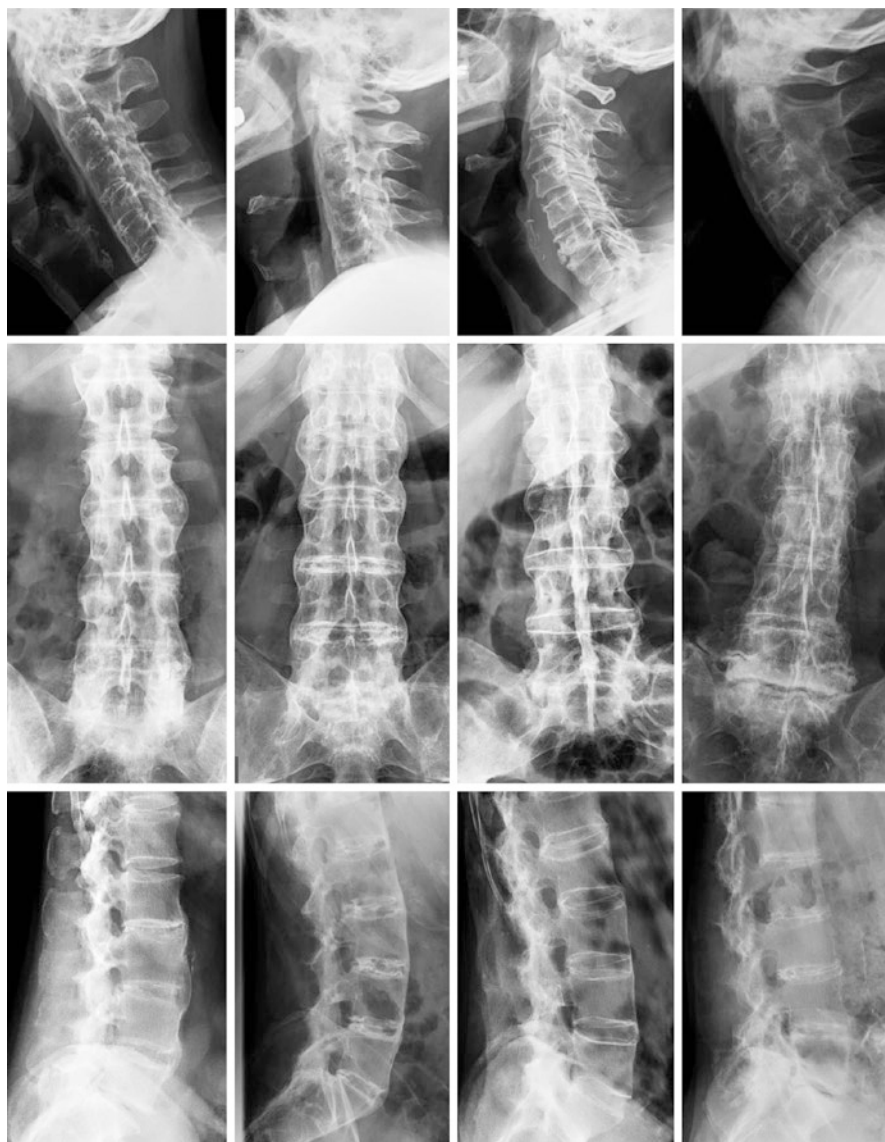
X-rays of different patients with ankylosing spondylitis on different stages
